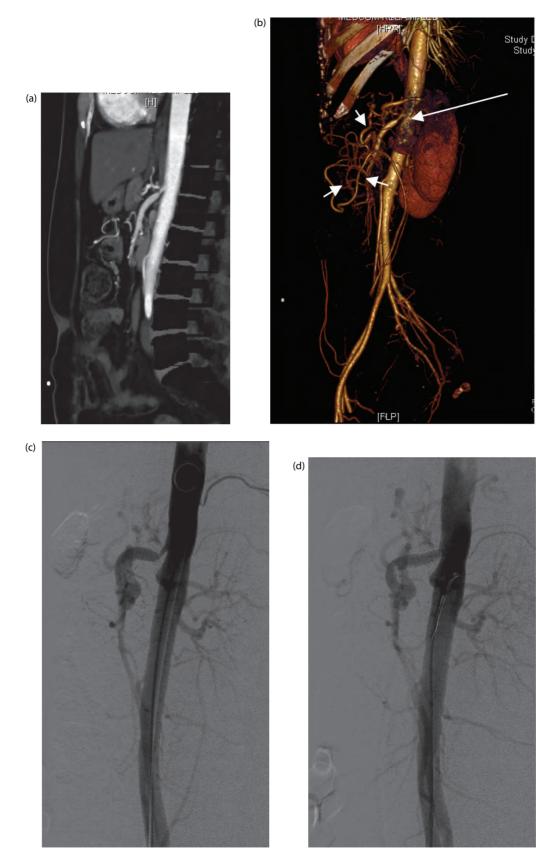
(a) Sagittal maximum intensity projection CT angiography shows severe stenosis of the superior mesenteric artery and occluded coeliac trunk at its origin. (b) Volume-rendering CT angiography image shows the stenosis of the superior mesenteric artery (long arrow) and visceral collaterals (short arrows). (c) Catheter angiography confirms the severe stenosis at the origin of the superior mesenteric artery. (d) Catheter angiography following stent angioplasty. Note complete resolution of the stenosis.
